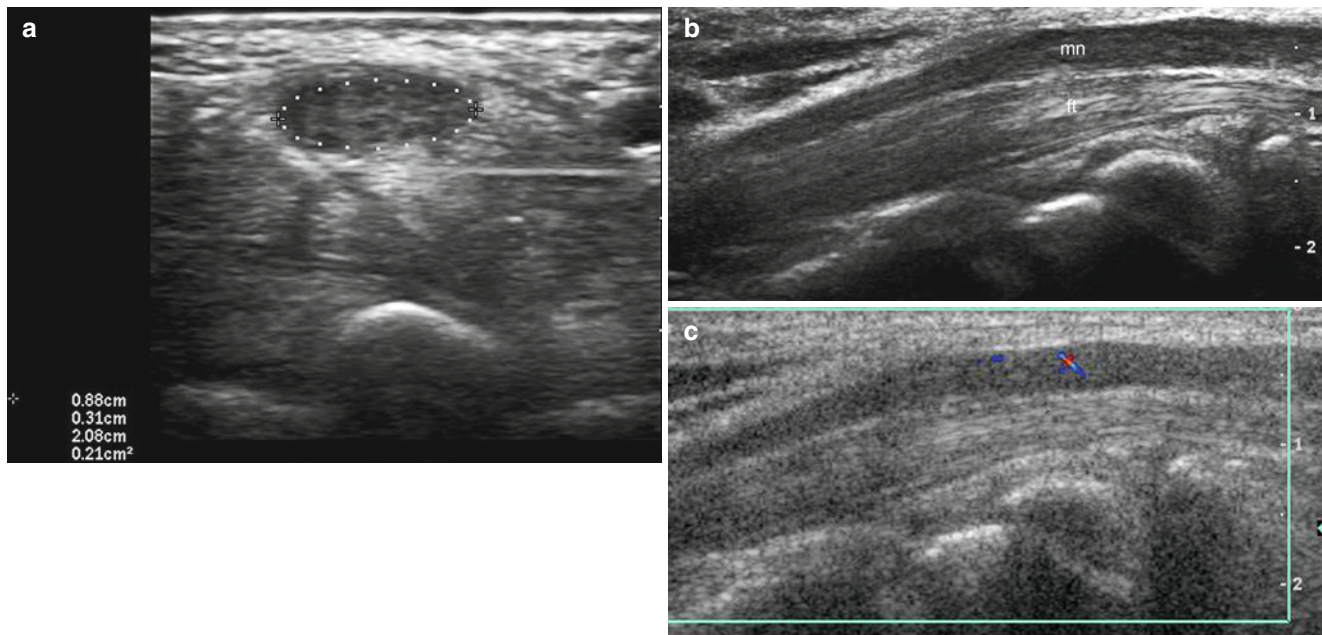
(a–c) Carpal tunnel syndrome. (a, b) Grey scale ultrasound images (a transverse view; b longitudinal view) demonstrate a median nerve (*mn*) with increased thickness and area (21 mm^2). (c) Color
